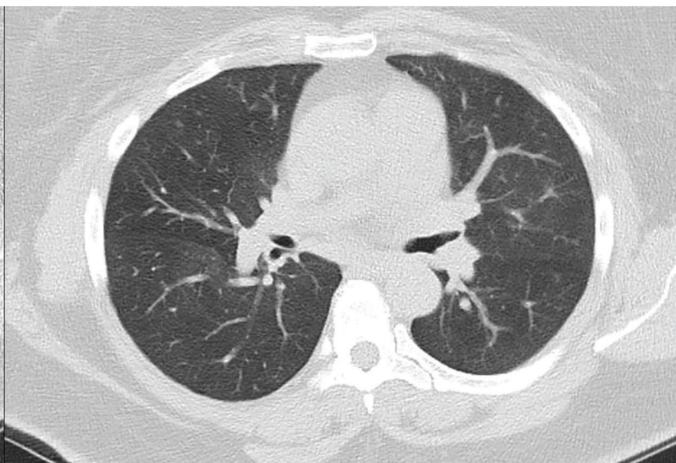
Axial Images of a CT Scan of the Chest During Inspiration (A) and During Expiration (B) Showing Air Trapping
